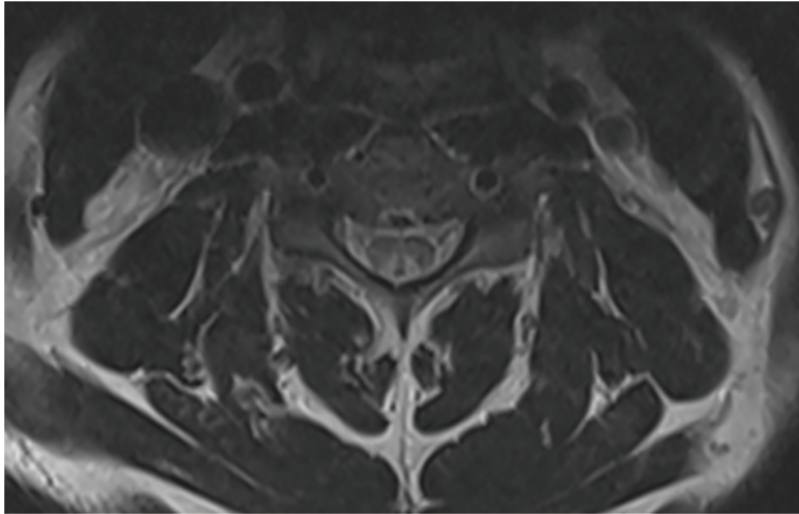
Magnetic resonance imaging of the cervical spine with a symmetric, bilateral, and high T2 signal in the dorsal columns, indicated by the characteristic inverted “V” or “bunny-ear” sign.
